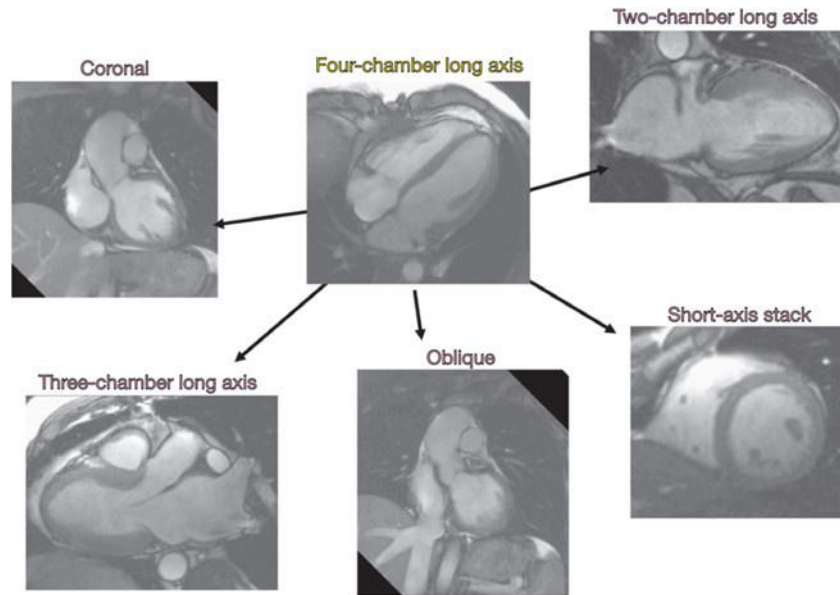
The planes of views of CMR imaging. Traditionally, CMR functional analysis uses the standard echocardiographic planes including the four-, three- and two-chamber long axis views and short axis views. From Daly, Abbasi and Kwong[26].
